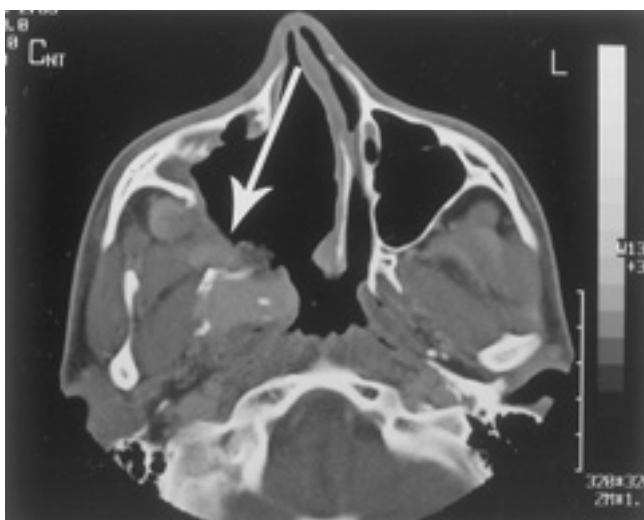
Postoperative CT scan shows excellent transnasal exposure (arrow), achieved by bone removal.
